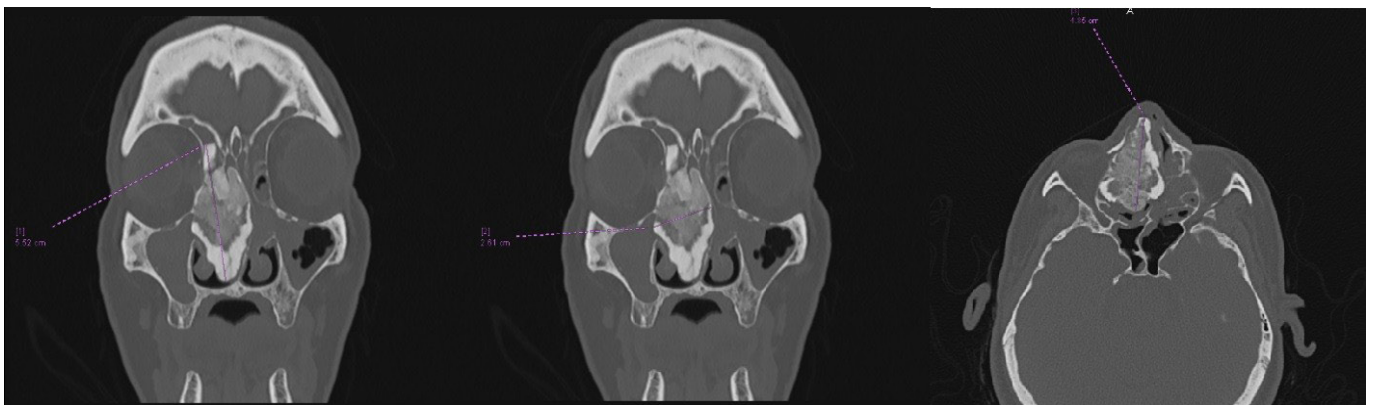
Paranasal Sinus CT Image
